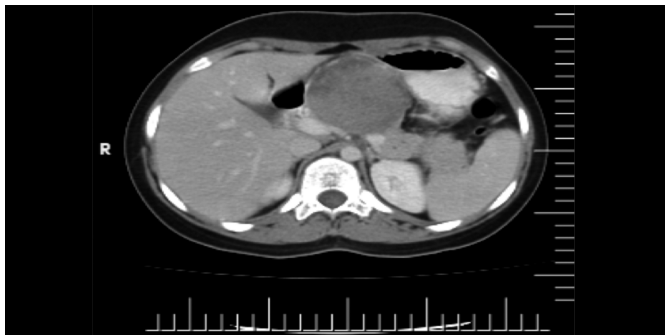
Preoperative CT scan showing pancreatic body tumour.
